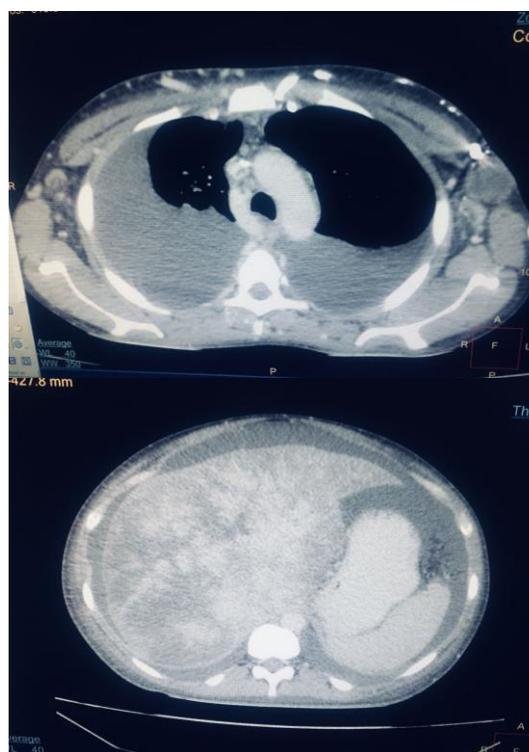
CT Scan showing mottled liver (arrow) and caudate lobe hypertrophy, ascites, and bilateral pleural effusion
